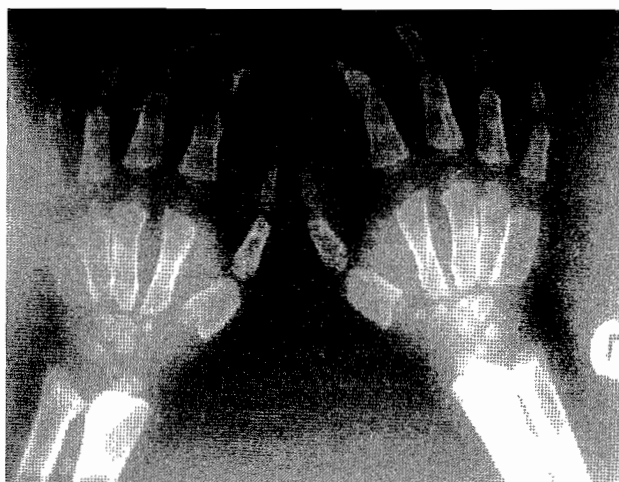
Plain radiograph of both hands showing coarse trabeculae with widened metacarpal shafts and narrowing or tapering of their proximal ends.
